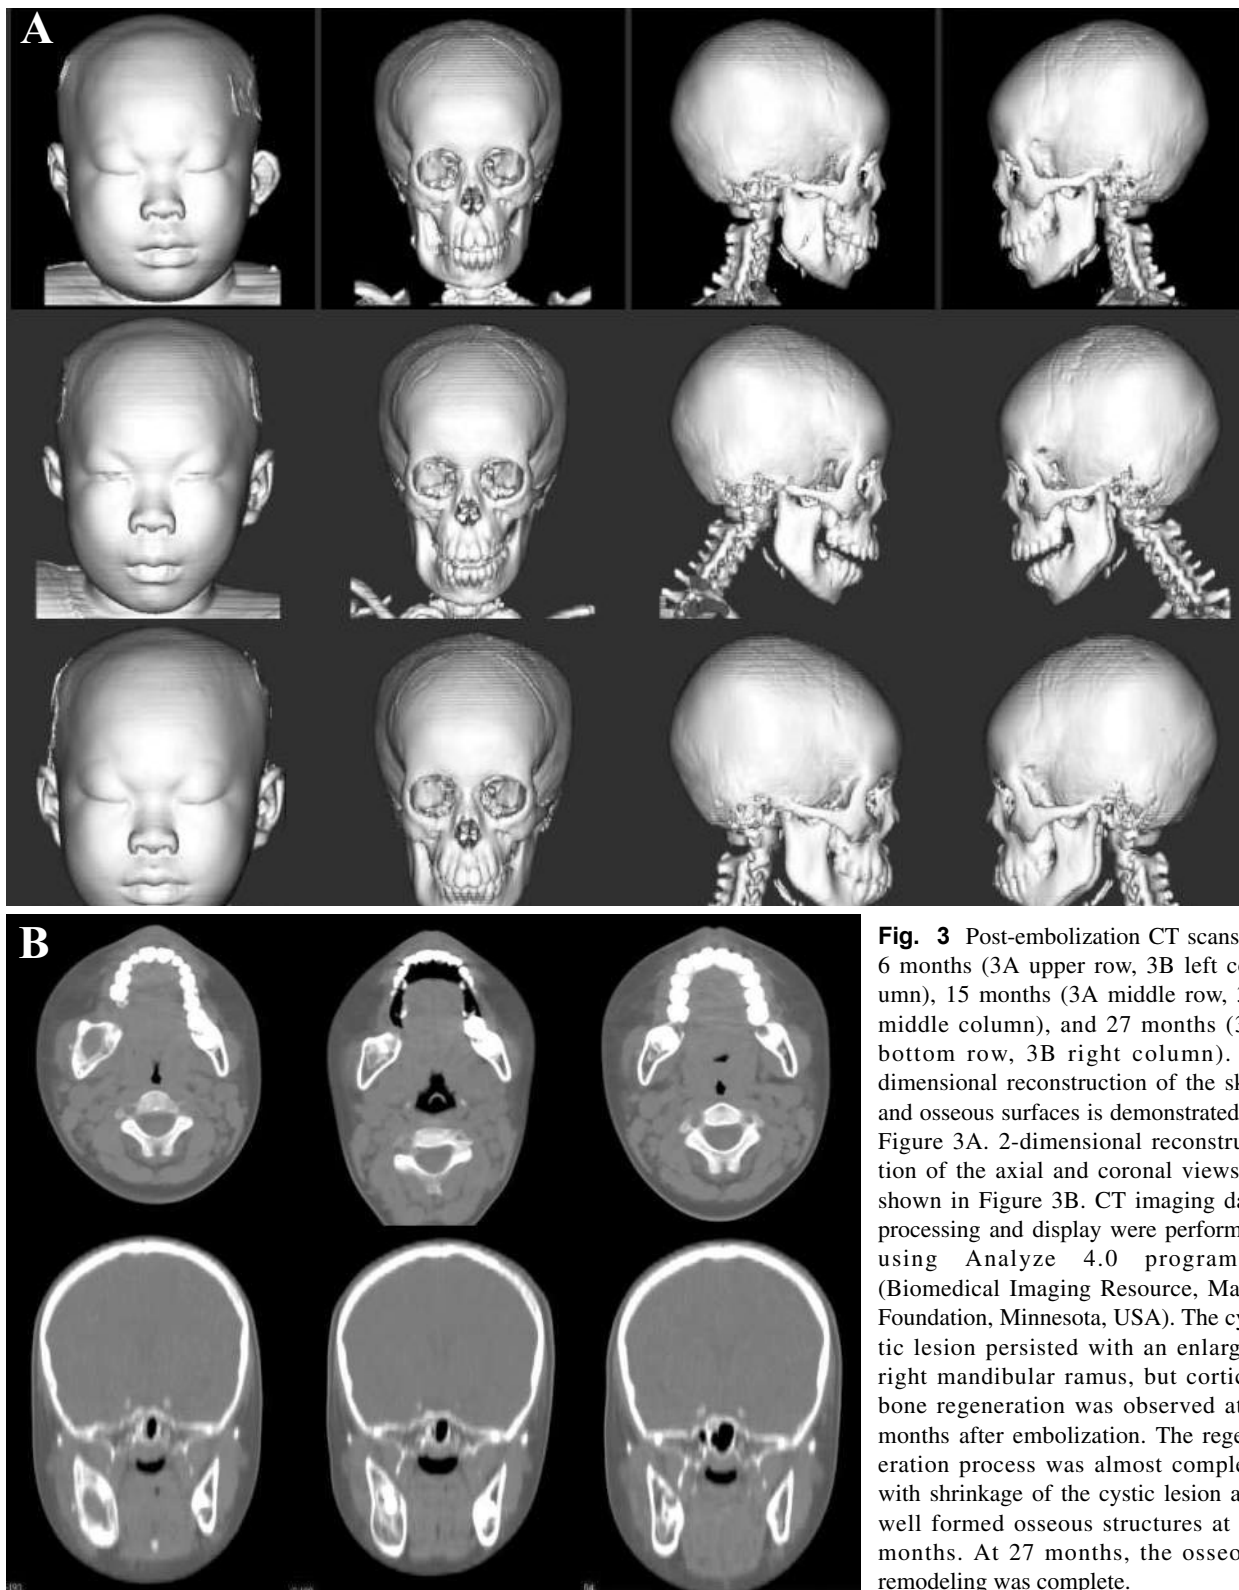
Post-embolization CT scans at 6 months (3A upper row, 3B left column), 15 months (3A middle row, 3B middle column), and 27 months (3A bottom row, 3B right column). 3-dimensional reconstruction of the skin and osseous surfaces is demonstrated in Figure 3A. 2-dimensional reconstruction of the axial and coronal views is shown in Figure 3B. CT imaging data processing and display were performed using Analyze 4.0 program¹³ (Biomedical Imaging Resource, Mayo Foundation, Minnesota, USA). The cystic lesion persisted with an enlarged right mandibular ramus, but cortical bone regeneration was observed at 6 months after embolization. The regeneration process was almost complete with shrinkage of the cystic lesion and well formed osseous structures at 15 months. At 27 months, the osseous remodeling was complete.
